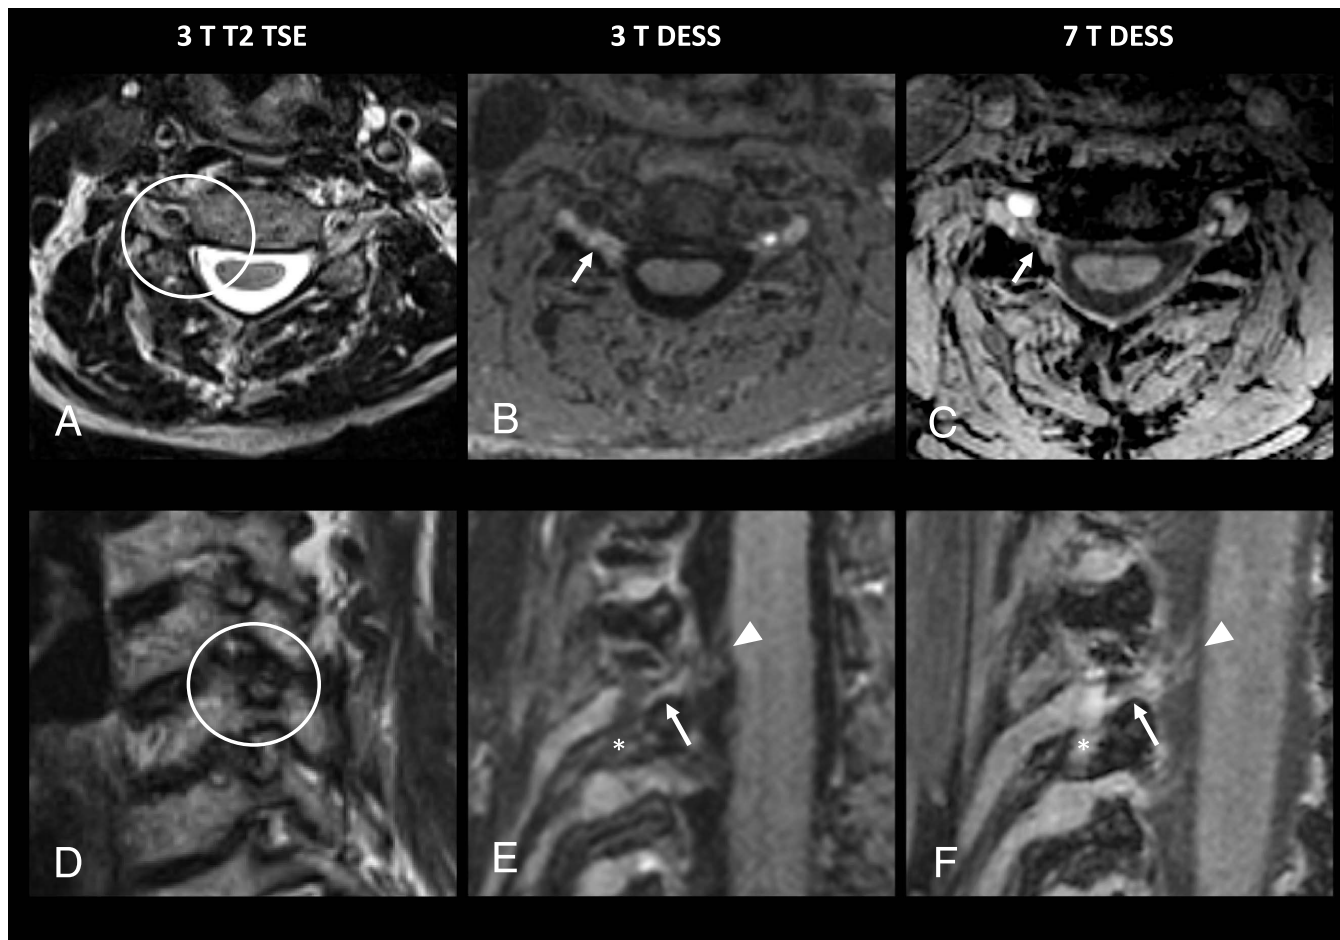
Multiplanar MRI scans of a patient with symptomatic cervical radiculopathy at the level of C6 of the right side. A and D, Images show a severe neuroforaminal stenosis on axial and oblique sagittal oblique conventional 3 T T2-weighted TSE images (circle). Multiplanar reformations of a 3D DESS sequence at 3 T (B and E) and 7 T (C and F) directly visualize the compressed cervical nerve root at the level of stenosis (arrows) as well as the attached cervical nerve rootlets (arrowhead). The asterisks are pointing on a partial overlay due to a cervical vein. TSE, turbo-spin echo.
